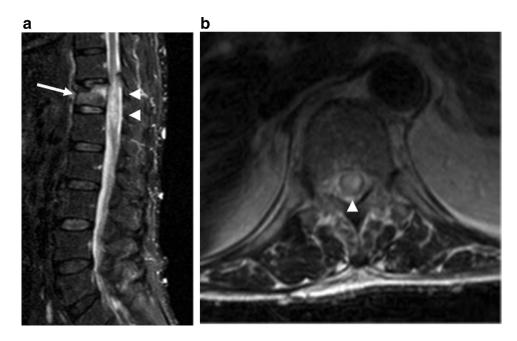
A 69-year-old male with NF1. MRI of the lumbar spine at the first admission just after fall. (A) Sagittal short TI inversion recovery image (STIR), (B) transverse T2WI at the level of Th12. There is a decrease in the height of T12 vertebral body with a bone marrow edema on sagittal STIR, which suggests a fresh compression fracture of Th12 (arrow). In addition, spinal cord swelling with intramedullary edematous change in the conus medullaris is also found at the level of Th12 on sagittal STIR and transverse T2WI (arrow heads). Therefore, the patient was diagnosed as having traumatic spinal cord injury associated with a compression fracture of Th12 from fall. There are multiple skin nodules in the lower back, suggesting multiple tiny neurofibromas.
